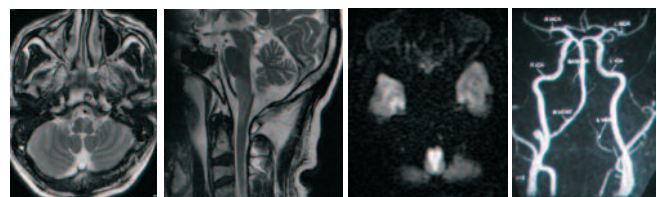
(a)T2WI Axial (b) T2WI Coronal (c) DWI Axial (d) 3D TOF Angiography
